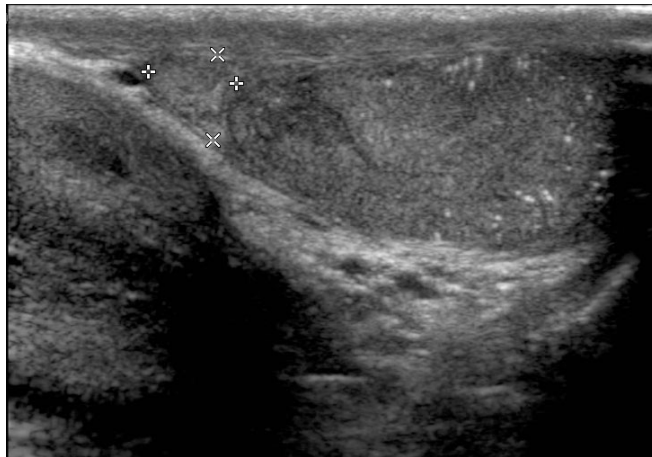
Scrotal ultrasound reveals an ill defined hypoechoic lesion of the upper pole of the right testicle, measuring around 1.0 x 1.2 cm.
